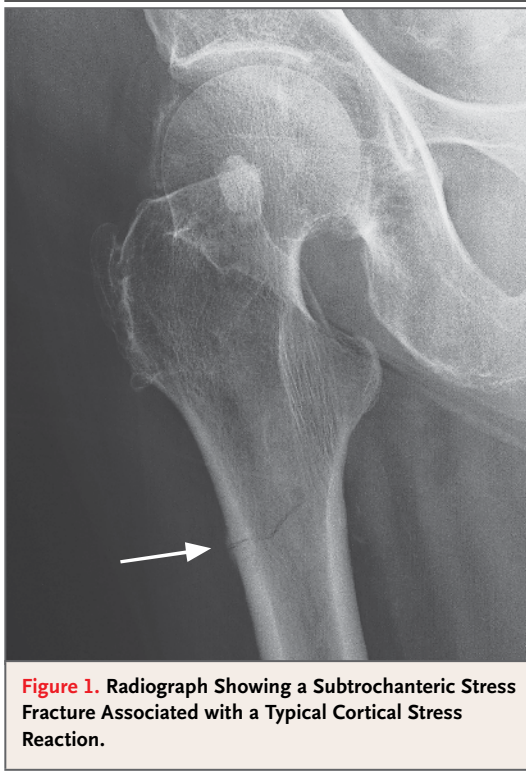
Radiograph Showing a Subtrochanteric Stress Fracture Associated with a Typical Cortical Stress Reaction.
